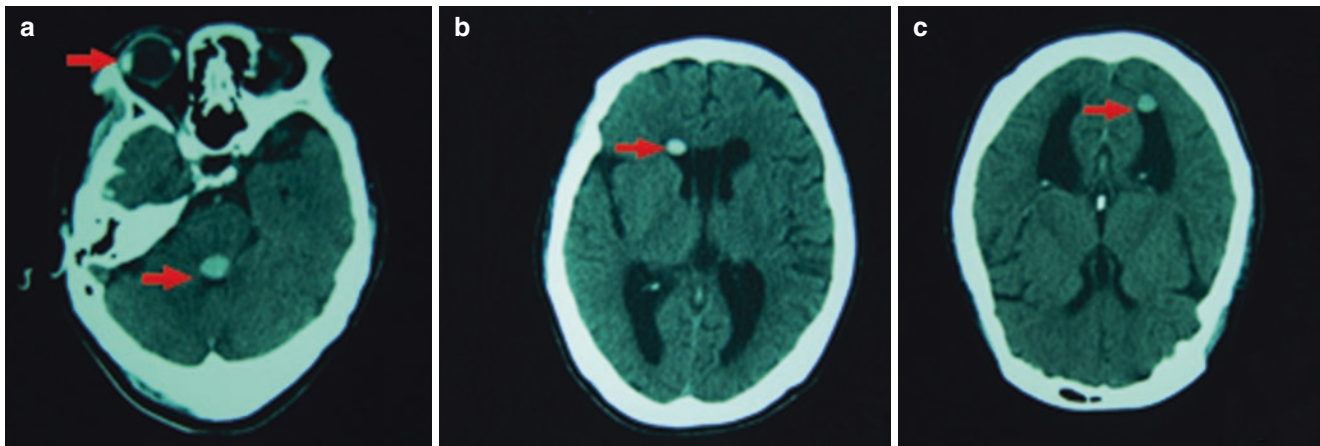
(a) Axial non-contrast head computed tomography (CT) reveals high signal intensity of the fourth ventricle (arrows), similar to the characteristics of the intravitreal silicone oil in the right eye (arrow).
